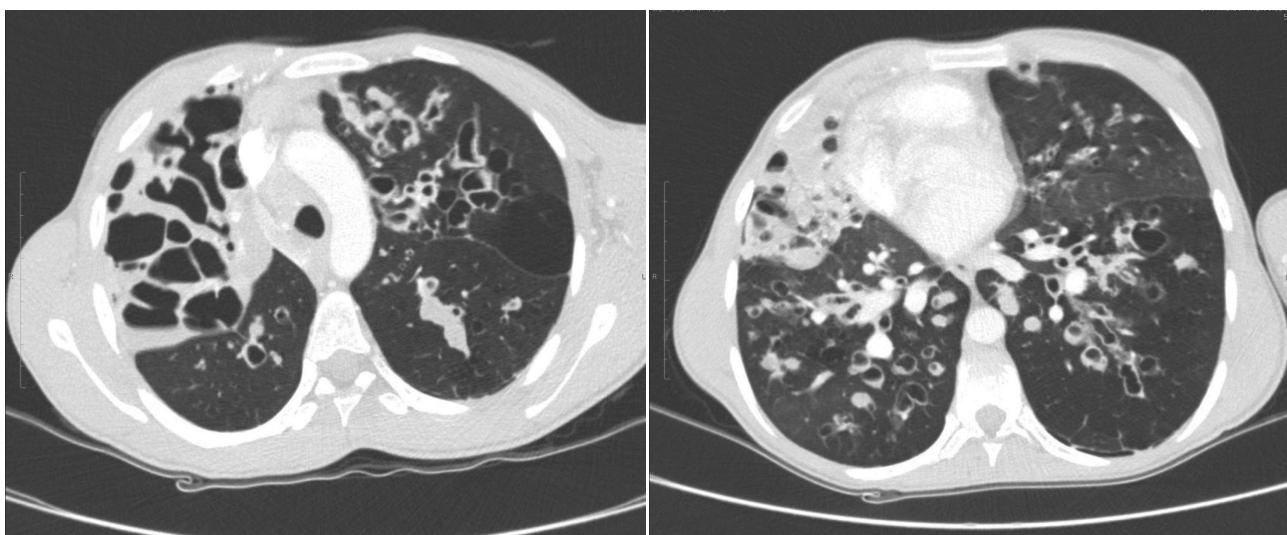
Chest computed tomography (CT) image revealing multiple bronchiectasis.
